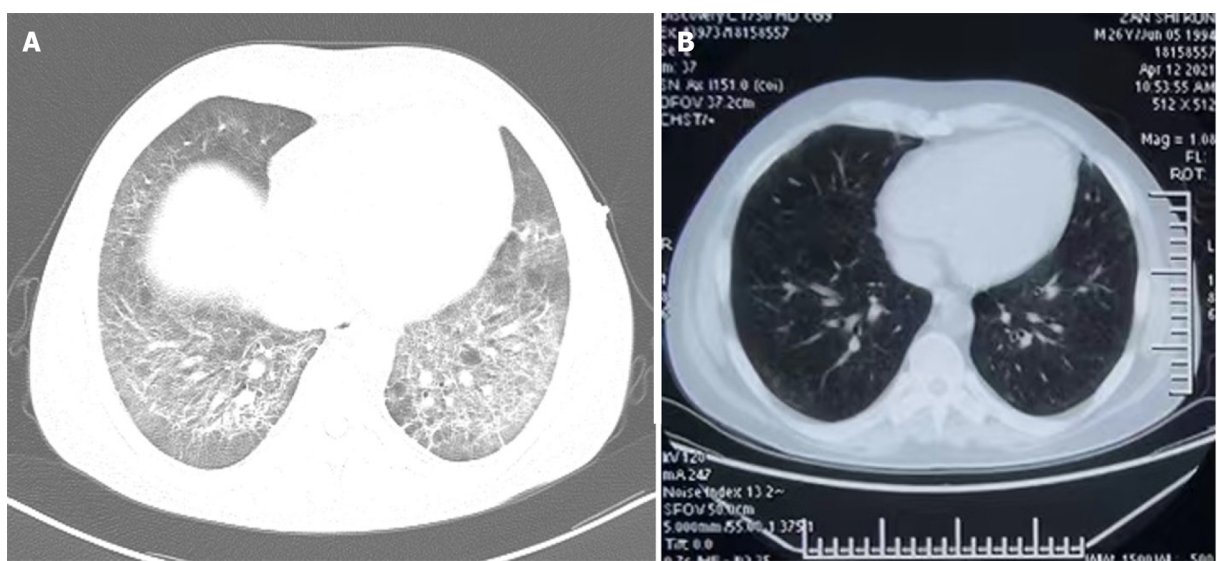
Chest computed tomography images before and after treatment with carrimycin. A: Chest computed tomography (CT) images before treatment with carrimycin; B: Chest CT images after treatment with carrimycin.
